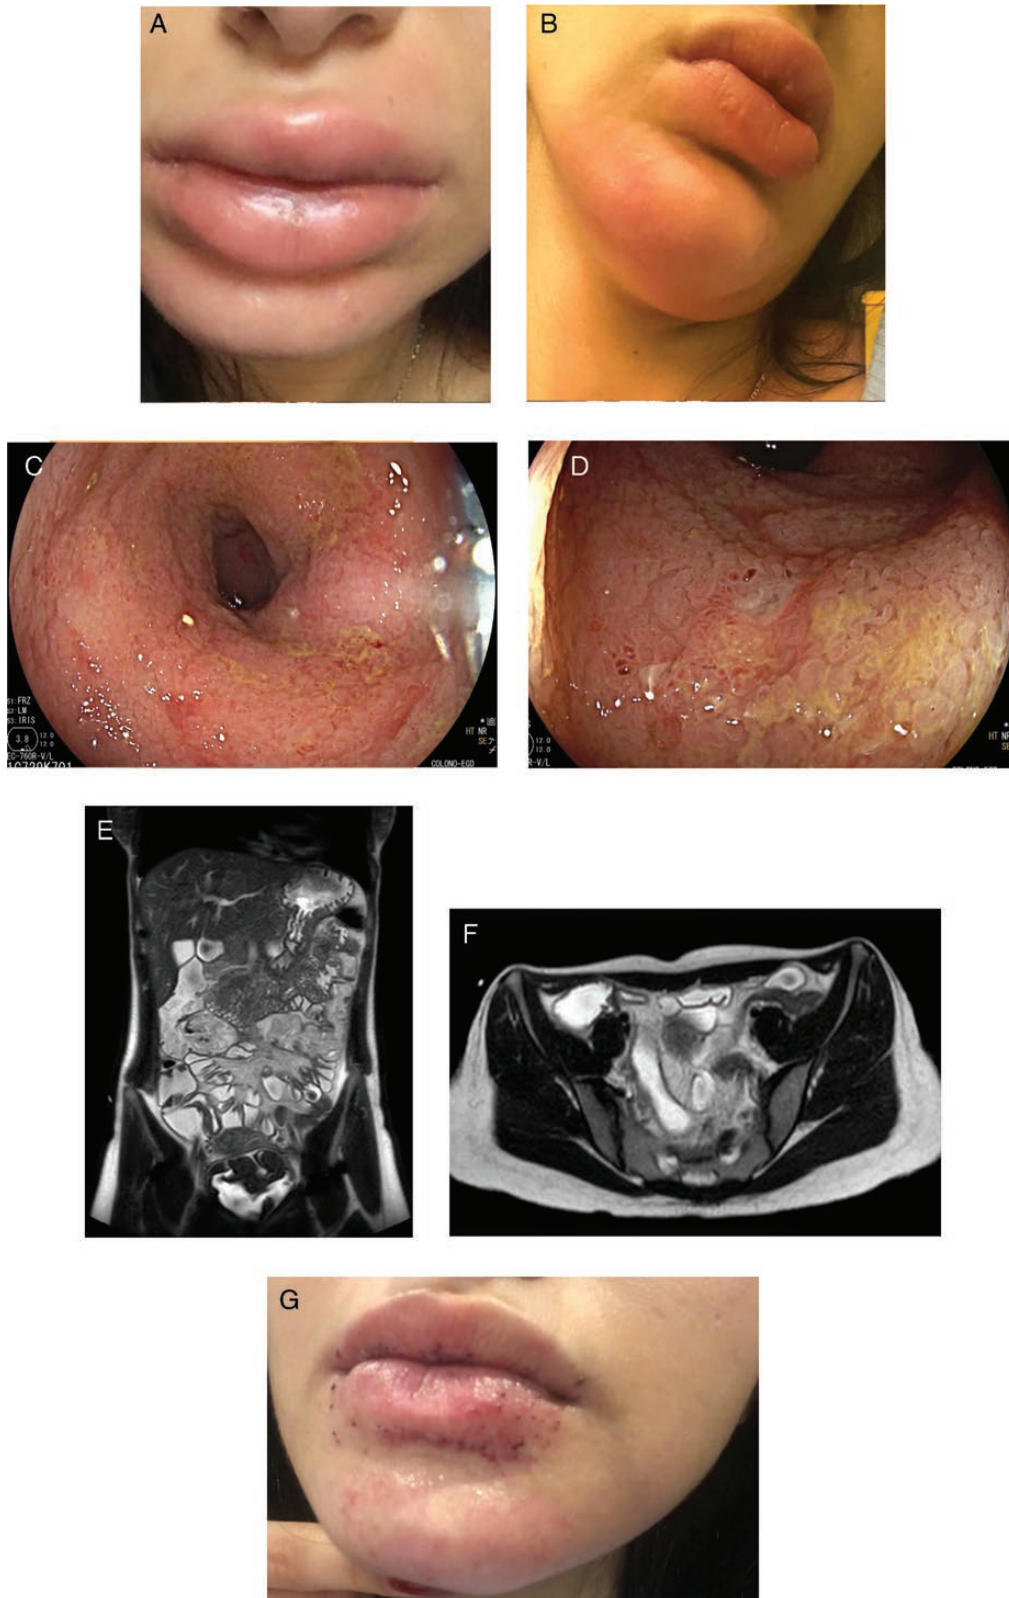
Photograph showing swelling of the patient's lips (A). Photograph showing pustules on the patient's lips as well as swelling and redness of her chin (B). Endoscopic appearance of the terminal ileum revealing congested mucosa, erythema and mild narrowing (C). Endoscopic appearance of a couple of ileal ulcers (D). Coronal cut of magnetic resonance imaging revealing small bowel Crohn's disease (E). Axial cut of magnetic resonance imaging revealing small bowel Crohn's disease (F). Photograph showing crusting over of the patient's pyostomatitis vegetans (G).
